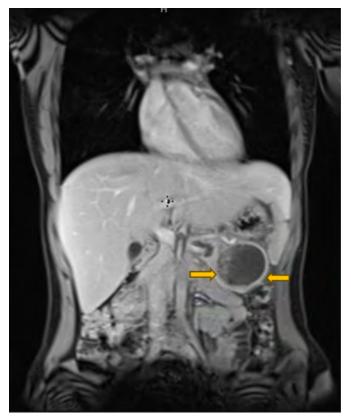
Abdominal MRI showing a complex mass in the tail of the pancreas. Note the thick wall of the mass and the peripheral nodular enhancement.
